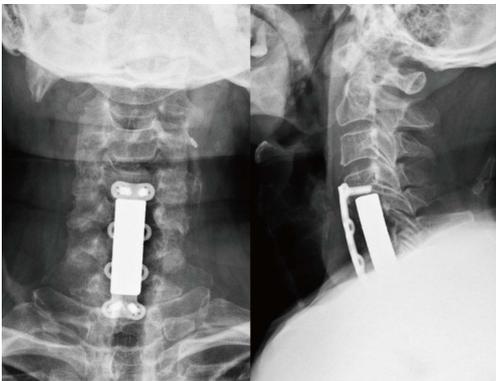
Single-stage anterior radical debridement and tantalum mesh cage implantation followed by supplemental anterior locked plate instrumentation were performed to treat infectious spondylitis and correct kyphotic deformity. Postoperative radiograph showed better alignment after single-stage anterior surgery for complicated infectious spondylitis.
